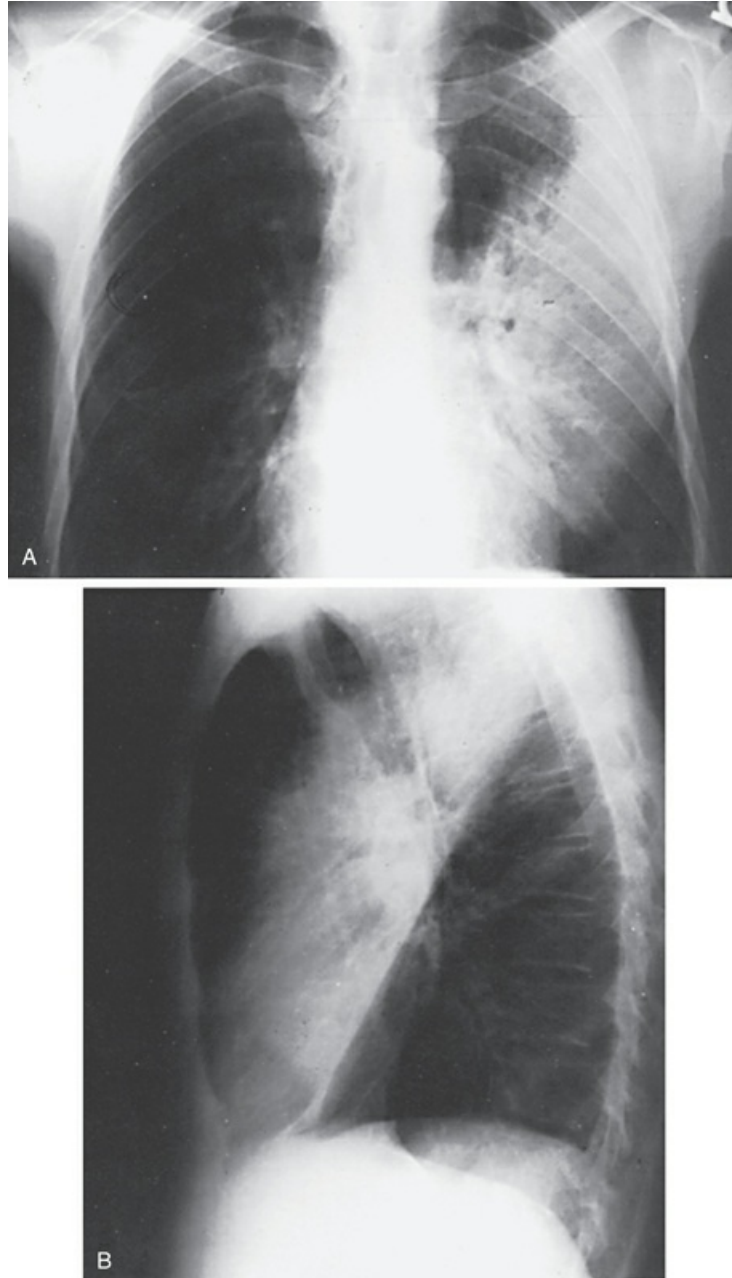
Posteroanterior (A) and lateral (B) chest radiographs of a patient with left upper lobe consolidation due to pneumonia. Anatomic boundary is best appreciated on the lateral view, where it is easily seen that a normally positioned major fissure defines the lower border of consolidation (compare with [Fig. 3.5](#)). Part of left upper lobe is spared. *Source:* (Courtesy Dr. T. Scott Johnson.)
